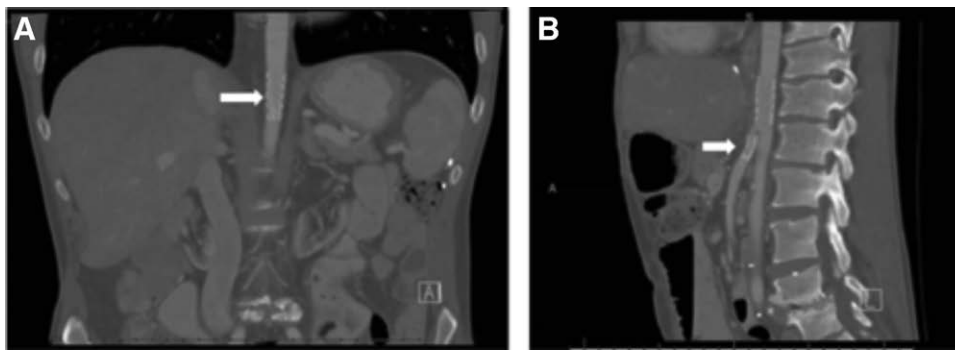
Computed tomography angiogram of the abdomen with 3-dimensional reconstruction showing a pseudoaneurysm (arrows) arising from the proximal segment of the supraceliac abdominal aorta to the donor hepatic artery bypass graft.
